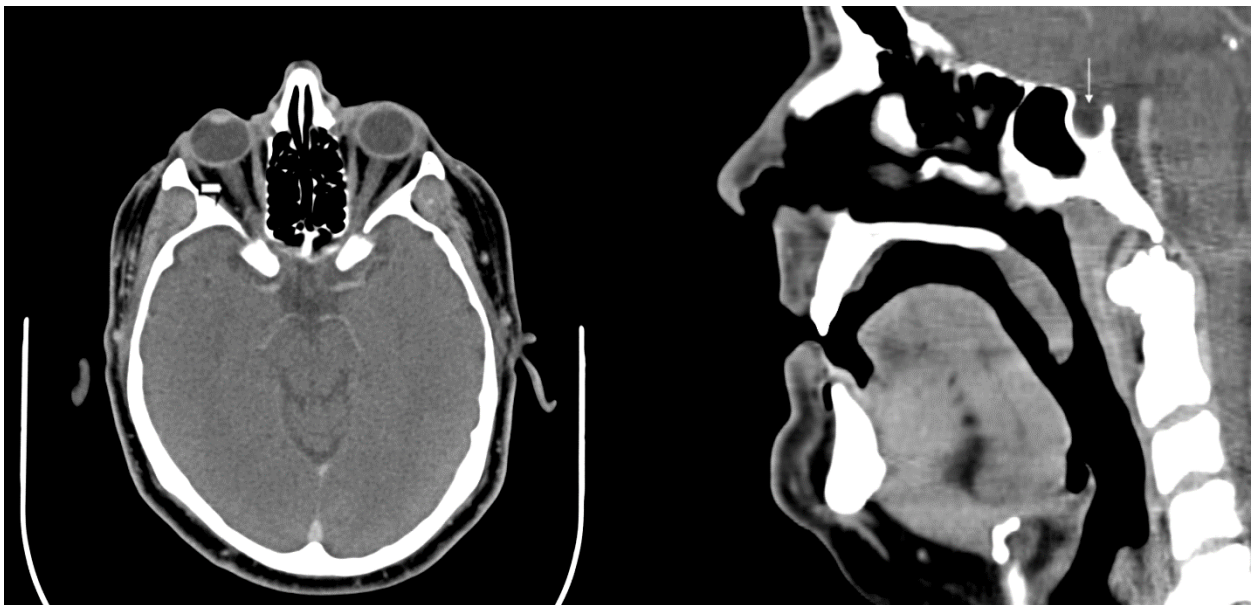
Axial CT neck soft tissue image with contrast at the level of the orbits demonstrates distension of the optic nerve sheath (short arrow). Sagittal CT soft tissue neck image demonstrates a partially empty sella (thin arrow) in the same patient with suspected idiopathic intracranial hypertension.
